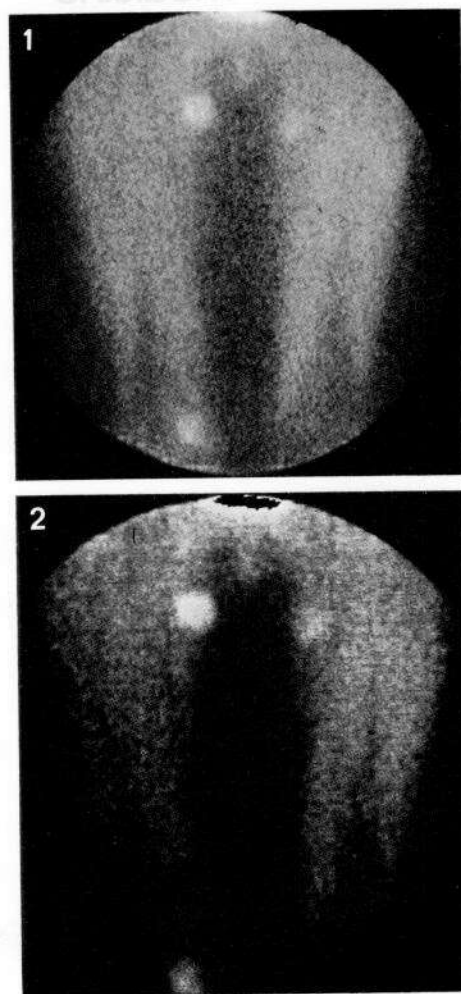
Anterior scintigram from Case 1 showing accumulation of ^{99m}Tc -labelled antibody F(ab')_2 fragments at 6 h in 2 melanoma metastases in the right thigh and 1 metastasis in the left thigh
